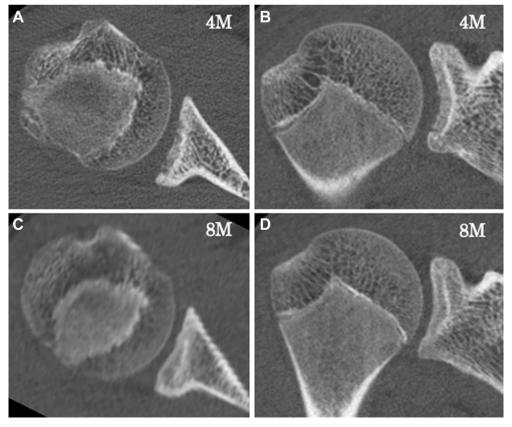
Computed tomography 4 months (A, B) and 8 months (C, D) after the first visit showed restoration in the lesion.
